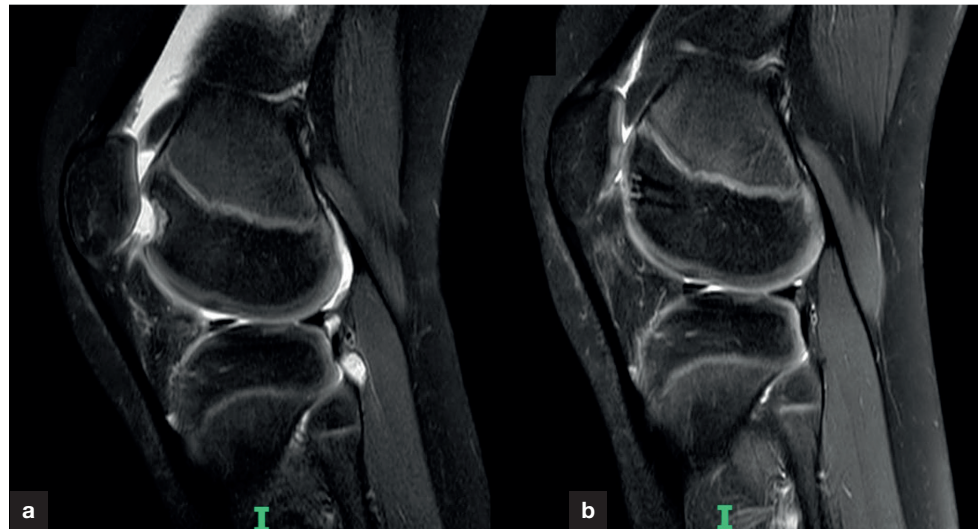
A sagittal T2-weighted magnetic resonance image slice of the knee demonstrating (a) trochlea osteochondritis dissecans that went on to heal and remodel following surgery as shown in (b) the 3-month postoperative interval scan.
